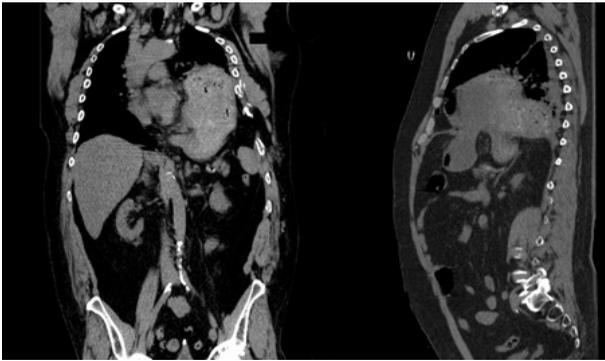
Case one, thoraco-abdominal contrast-enhanced CT-scan, coronal and sagittal section: dislocated stomach in the left pleural cavity
